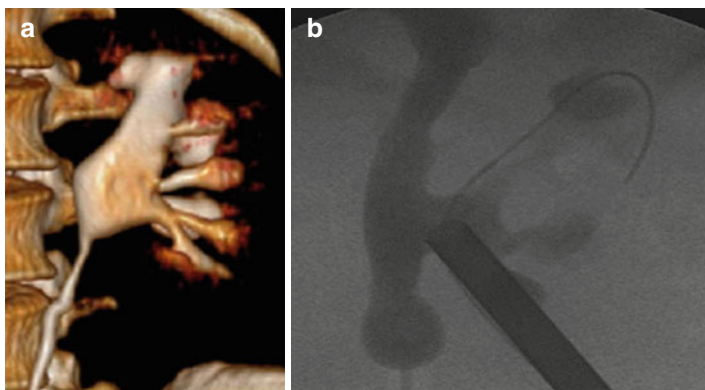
(a) Preoperative 3D-CT pyelography, demonstrating inferior calyces with rather thin infundibula; (b) intraoperative pyelography with a 30 F Amplatz sheath in place, after retrograde irrigation and dynamic dilation of the infundibulum of the accessed inferior calyx, which turned out to be rather elastic and compliant
